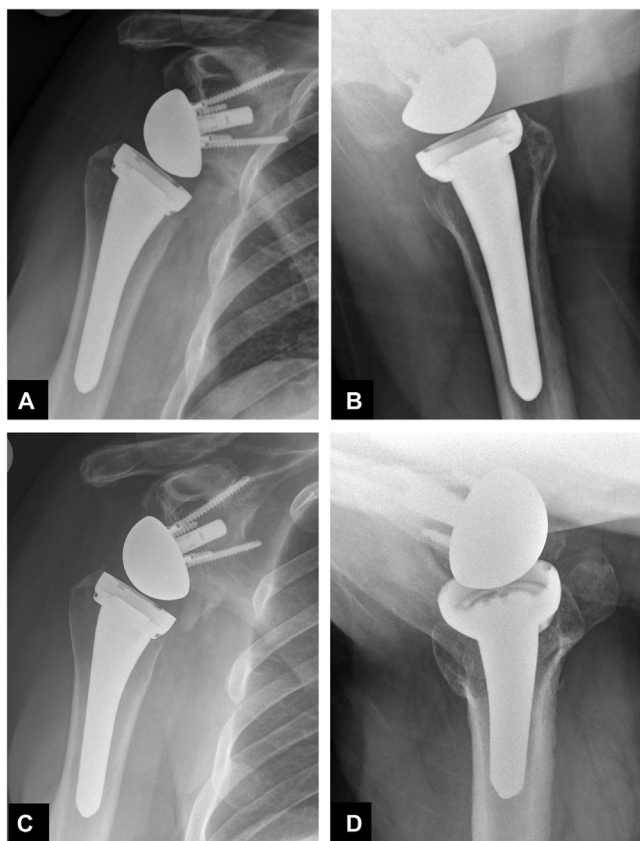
AP and axillary radiographs obtained at 3 (A and B) and 12 (C and D) months from date of surgery demonstrate maintained implant alignment without evidence of complication. AP, anterior posterior.
